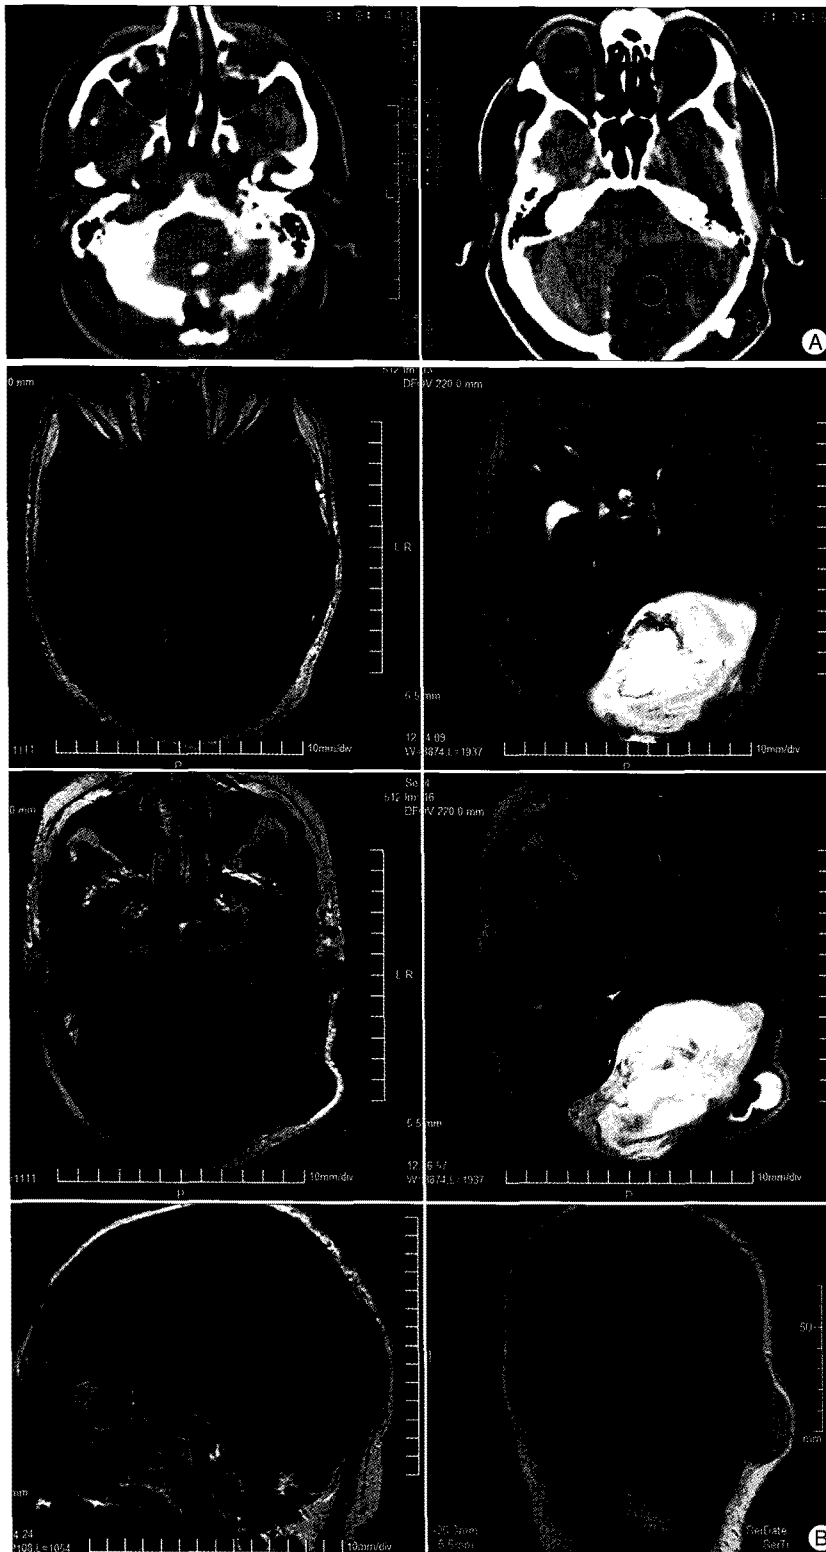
Images of posttraumatic giant intradiploic epidermoid cyst of posterior cranial fossa in the present case. A : Preoperative computed tomographic (CT) scans show giant infratentorial extracerebellar hypodense lesion with extensive occipital bone destruction and substantial mass effect in the posterior cranial fossa. B : Preoperative magnetic resonance (MR) images show giant infratentorial extradural intradiploic tumour, inhomogeneously hypointense in T1-weighted images (left) and hyperintense in T2-weighted (right), with an enhancement rim of the thickened dura mater and significant compression of the cerebellum, brain stem, fourth ventricle and the left occipital lobe, without corresponding brain oedema.
